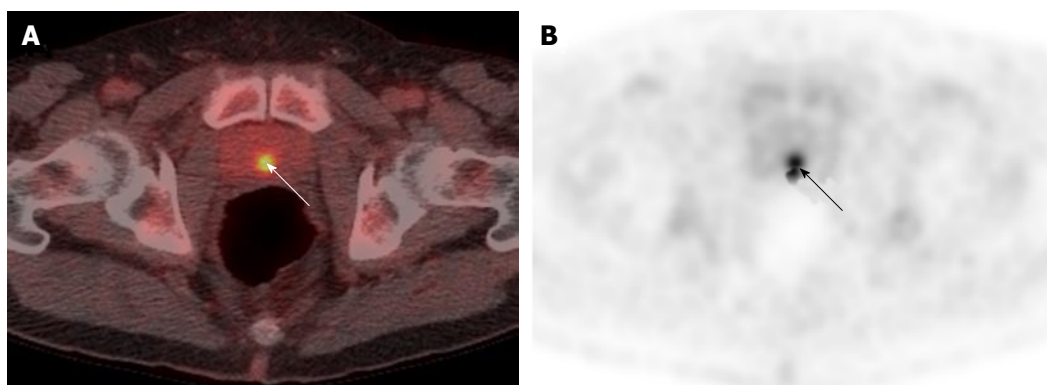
Midline uptake on ^{18}F -labelled fluorodeoxyglucose positron emission tomography/computed tomography in a 71-year-old man with oesophageal carcinoma and serum prostate specific antigen of 4.58 ng/mL. A, B: Fused PET/CT and PET-only imaging shows focal uptake in the midline of the prostate (arrowed). The uptake was considered to be tracer in the urethra given its anatomical location. PET/CT: Positron emission tomography/computed tomography.
